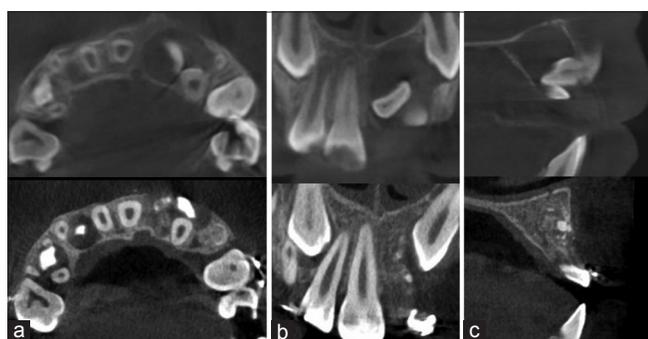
Cone-beam computed tomography: (a) axial view, pre- and post-operative, (b) coronal view, pre- and post-operative, and (c) sagittal view, pre- and post-operative
